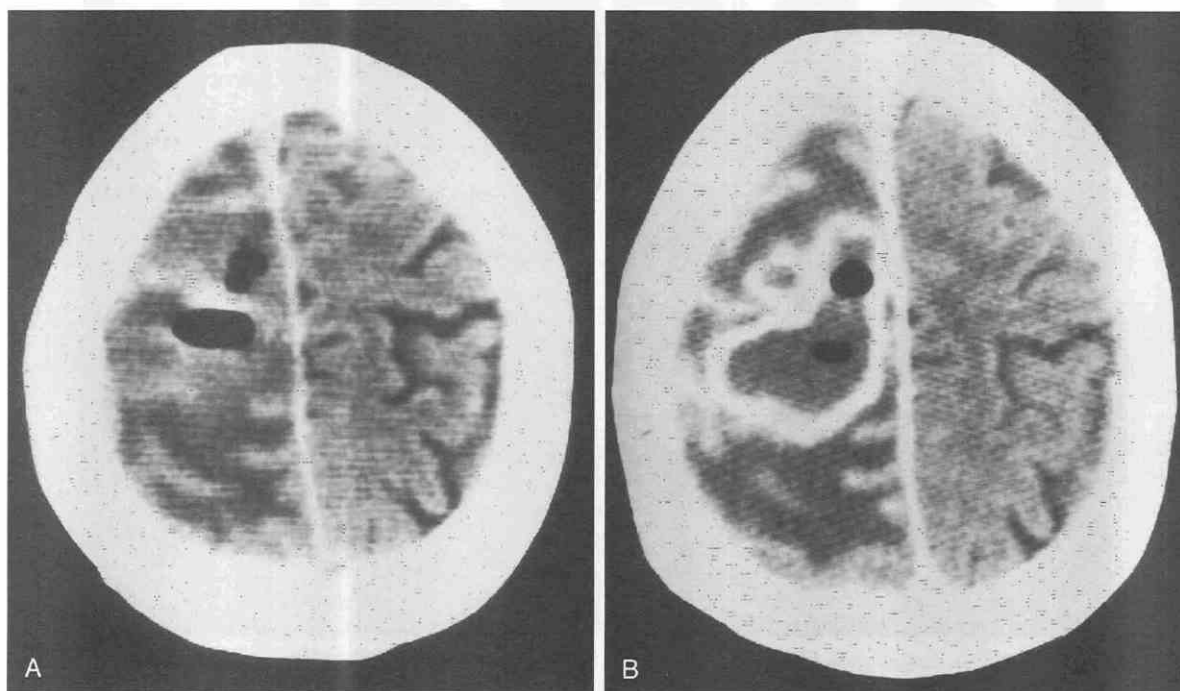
Abscess caused by gas-forming organism. A, Gas is seen with a surrounding low-density area on noncontrast CT scan. B, Contrast CT scan shows irregular, ringlike enhancement; gas is visible within the cavity. The causative organism was *Escherichia coli*.
